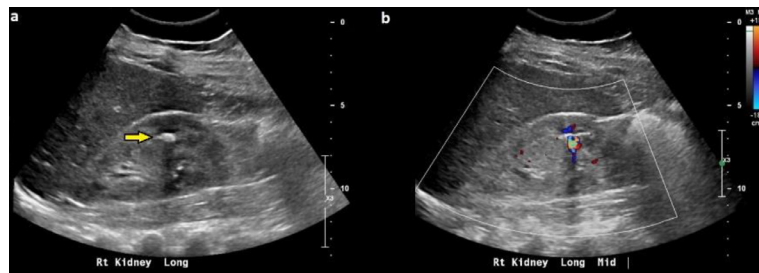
Renal ultrasound (US) of the right kidney demonstrating increased parenchymal echogenicity (A, B) and mid/lower calyceal nonobstructing stones (arrow) depicted by twinkling artifact with color Doppler (B).
